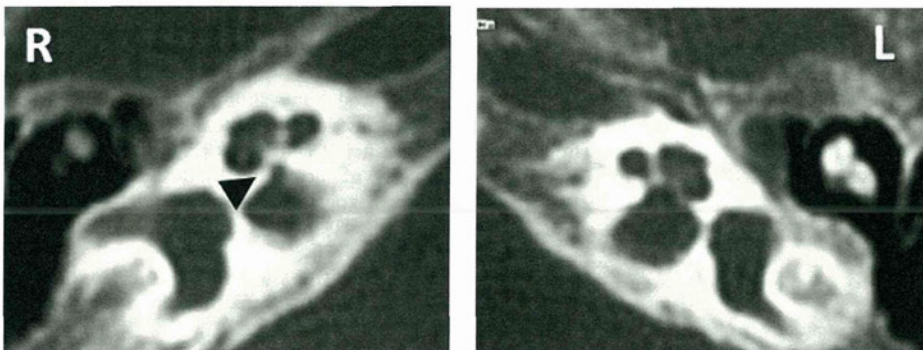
Cochlear nerve canal stenosis demonstrated by transverse, thin-section CT scan of the temporal bone in three-month old boy. The left panel shows the hearing-impaired right ear (R), and the right panel shows the normal left ear (L). The arrowhead indicates the stenotic cochlear nerve canal in the right ear.
